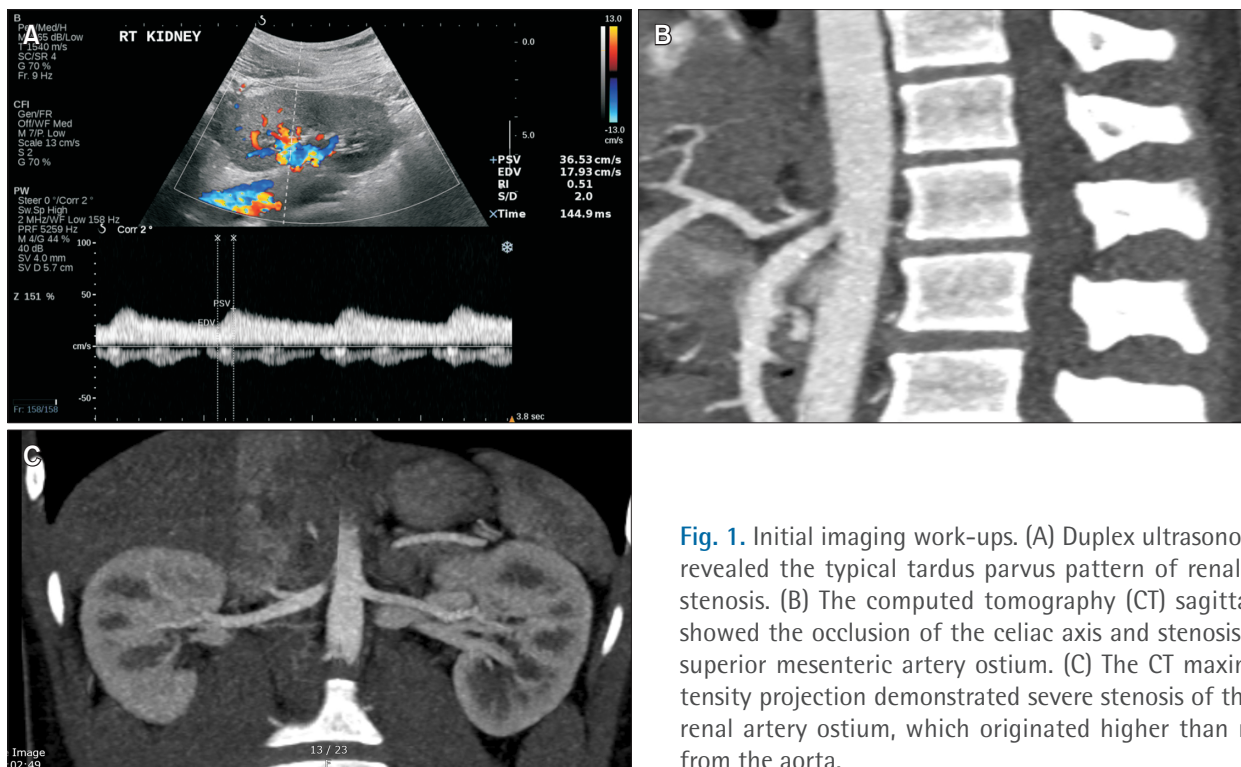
Initial imaging work-ups. (A) Duplex ultrasonography revealed the typical tardus parvus pattern of renal artery stenosis. (B) The computed tomography (CT) sagittal view showed the occlusion of the celiac axis and stenosis of the superior mesenteric artery ostium. (C) The CT maximal intensity projection demonstrated severe stenosis of the right renal artery ostium, which originated higher than normal from the aorta.
